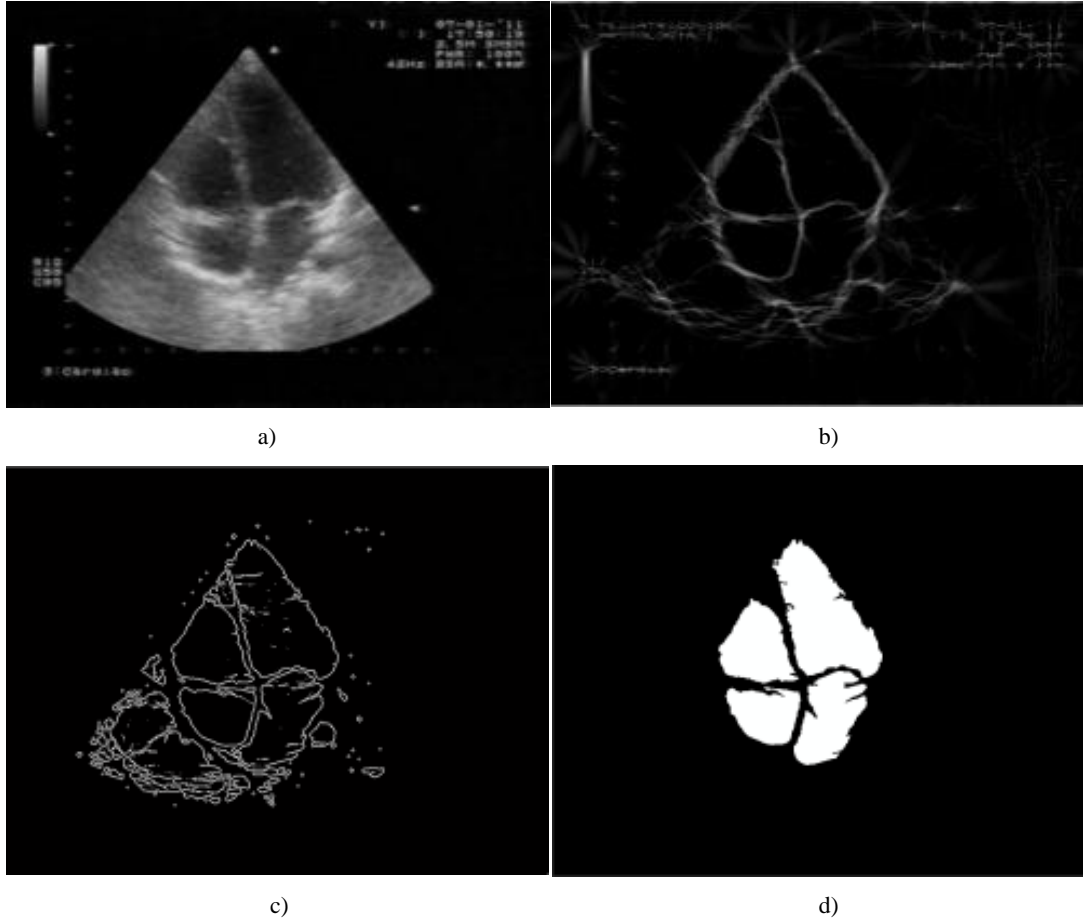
Echocardiographic image: (a) original Image, (b) detecting low-level features, (c) applying the segmentation method, (d) regions during post-processing.
